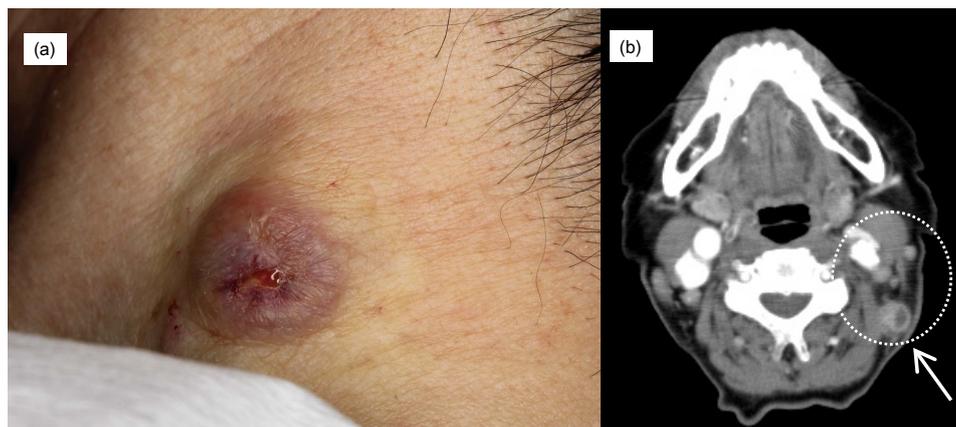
Clinical appearance (a) and computed tomography (b) in Case 2. (a) The lesion presented as a hard brownish nodule measuring 3 cm in diameter with no signs on the left cervical region. (b) Multiple lymph node swellings were found in the left cervical region.
